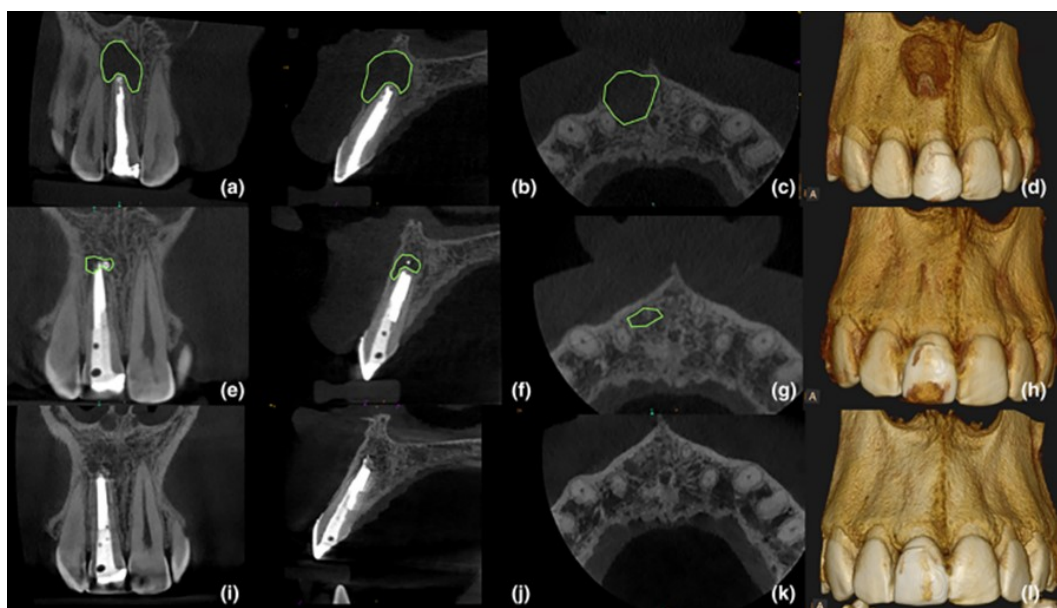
CBCT images of periapical bone healing on alveolar abscess²⁵
